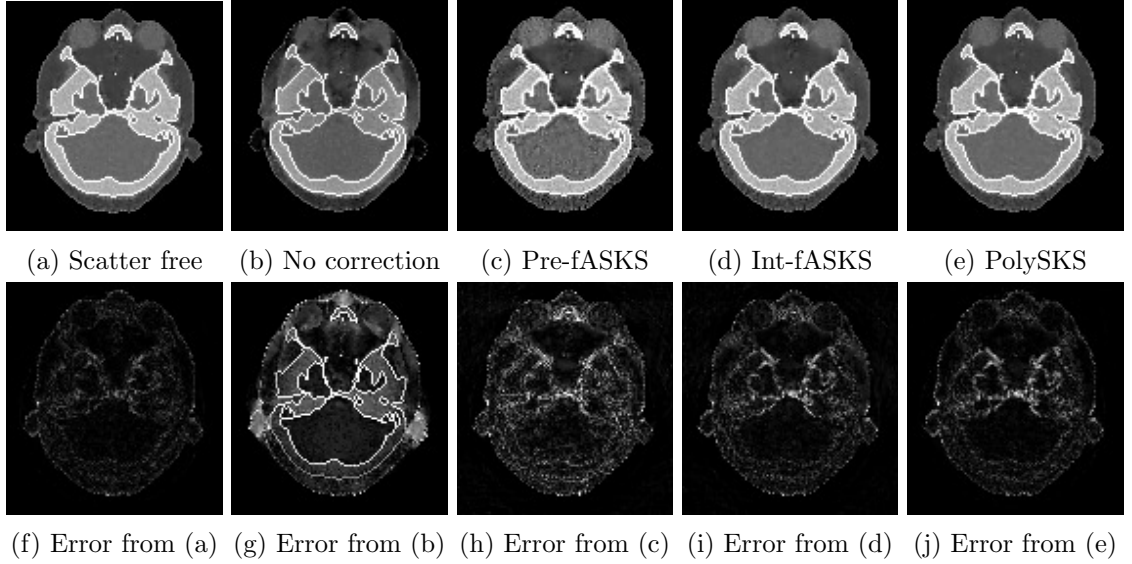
Visual results of slice 36 from the head CBCT data with display window  $[0.8, 1.4]$  to aid visualisation of soft tissue and reconstruction artefacts; absolute errors have display window  $[0, 0.3]$ .
